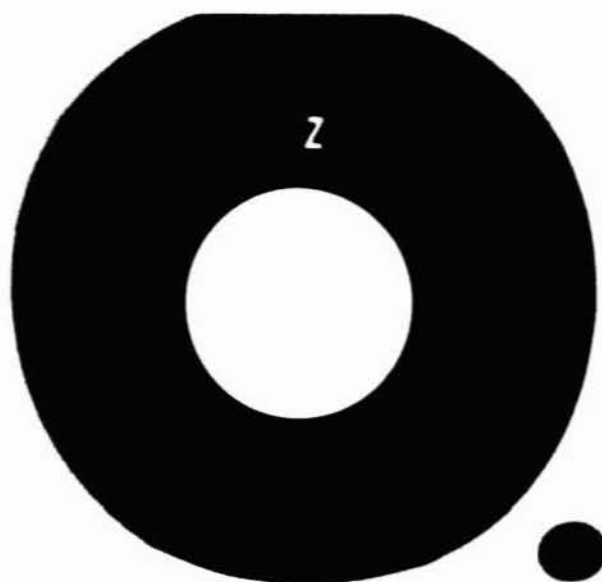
X-ray photographs of NR-150ZnO system (using cone)
